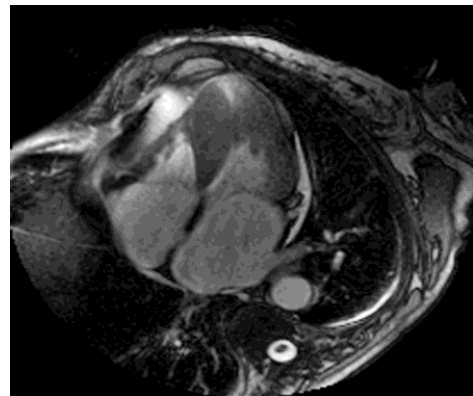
4 Chamber T2 weighted cardiac magnetic resonance image revealing presence of apical hypertrophy with apical pouch.
